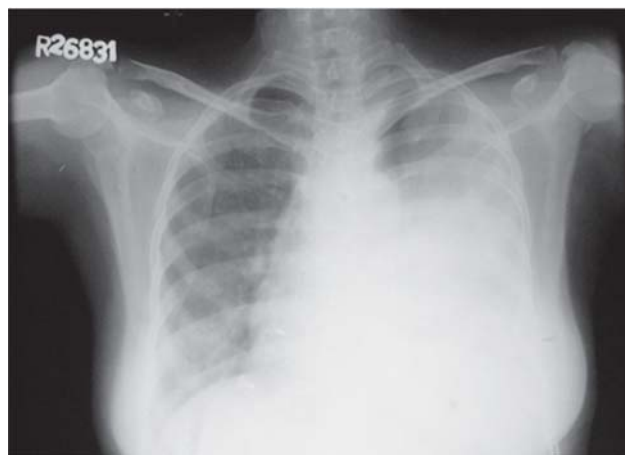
Chest radiograph (postero-anterior view) showing a homogeneous opacity in the left middle and lower zone. Air-bronchogram is not evident. Left costophrenic and cardiophrenic angles are obscured.
